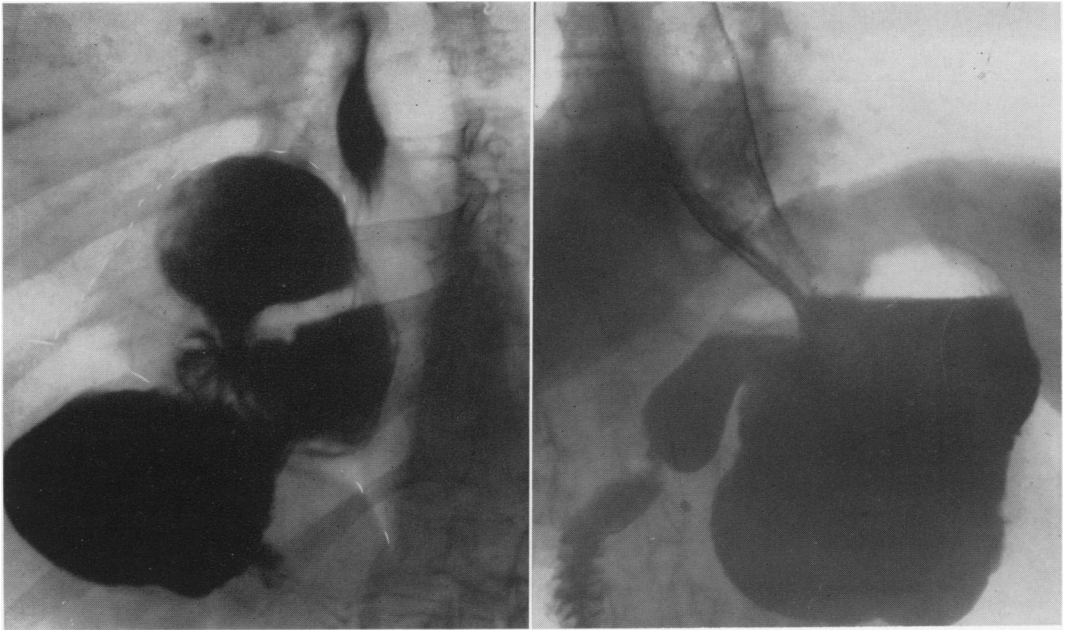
Showing x-ray findings in a para-esophageal hernia before and after gastropexy.
